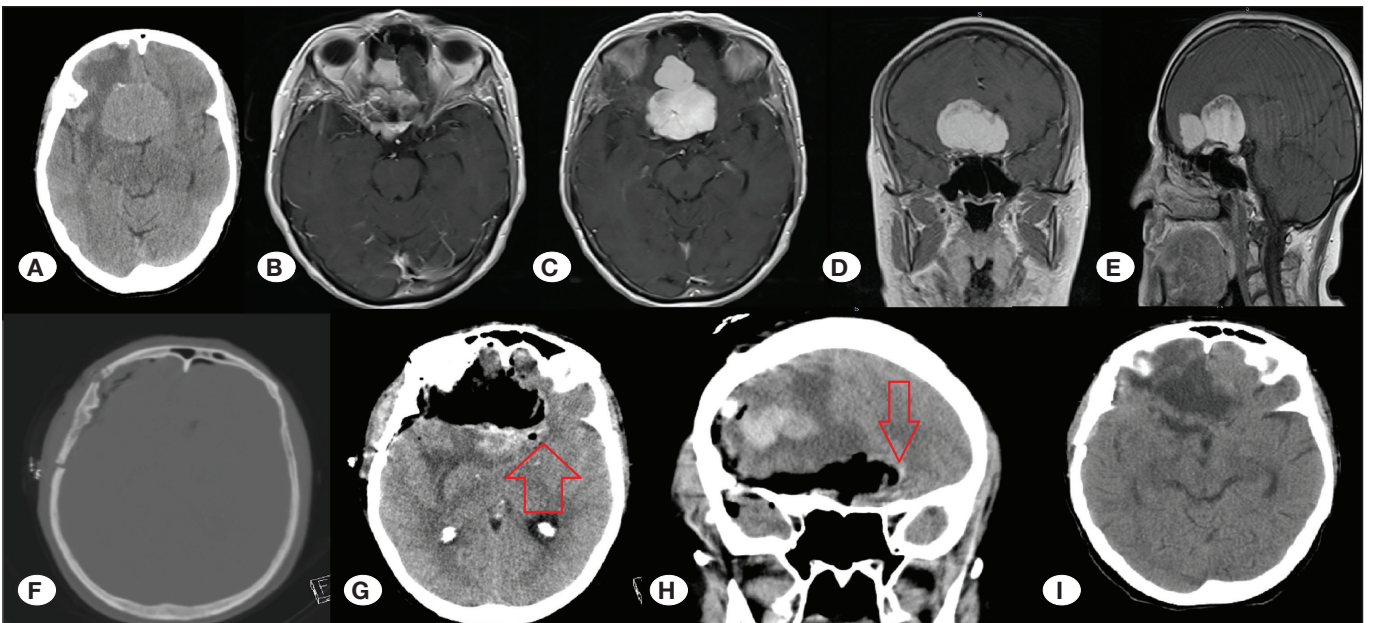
Preoperative axial computed tomography (CT) (A) and axial (B, C), coronal (D), and sagittal (E) contrast-enhanced T1-weighted MR sequence images showing a large olfactory groove meningioma. Craniotomy borders are visible on CT scan (F). Postoperative CT images (G, H) confirming total excision of the mass (the red arrows show the area reaching the opposite side with a unilateral extended pterional approach). I) Postoperative 3-month follow-up cranial CT scan confirming total excision of the mass lesion.
